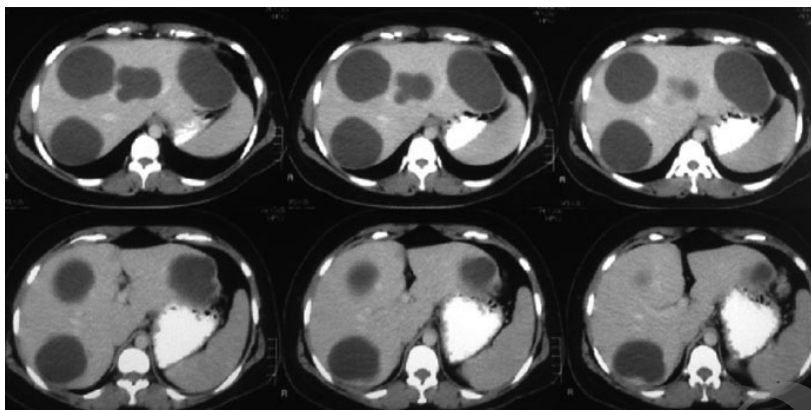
An abdominal CT scan showing multiple liver cysts
